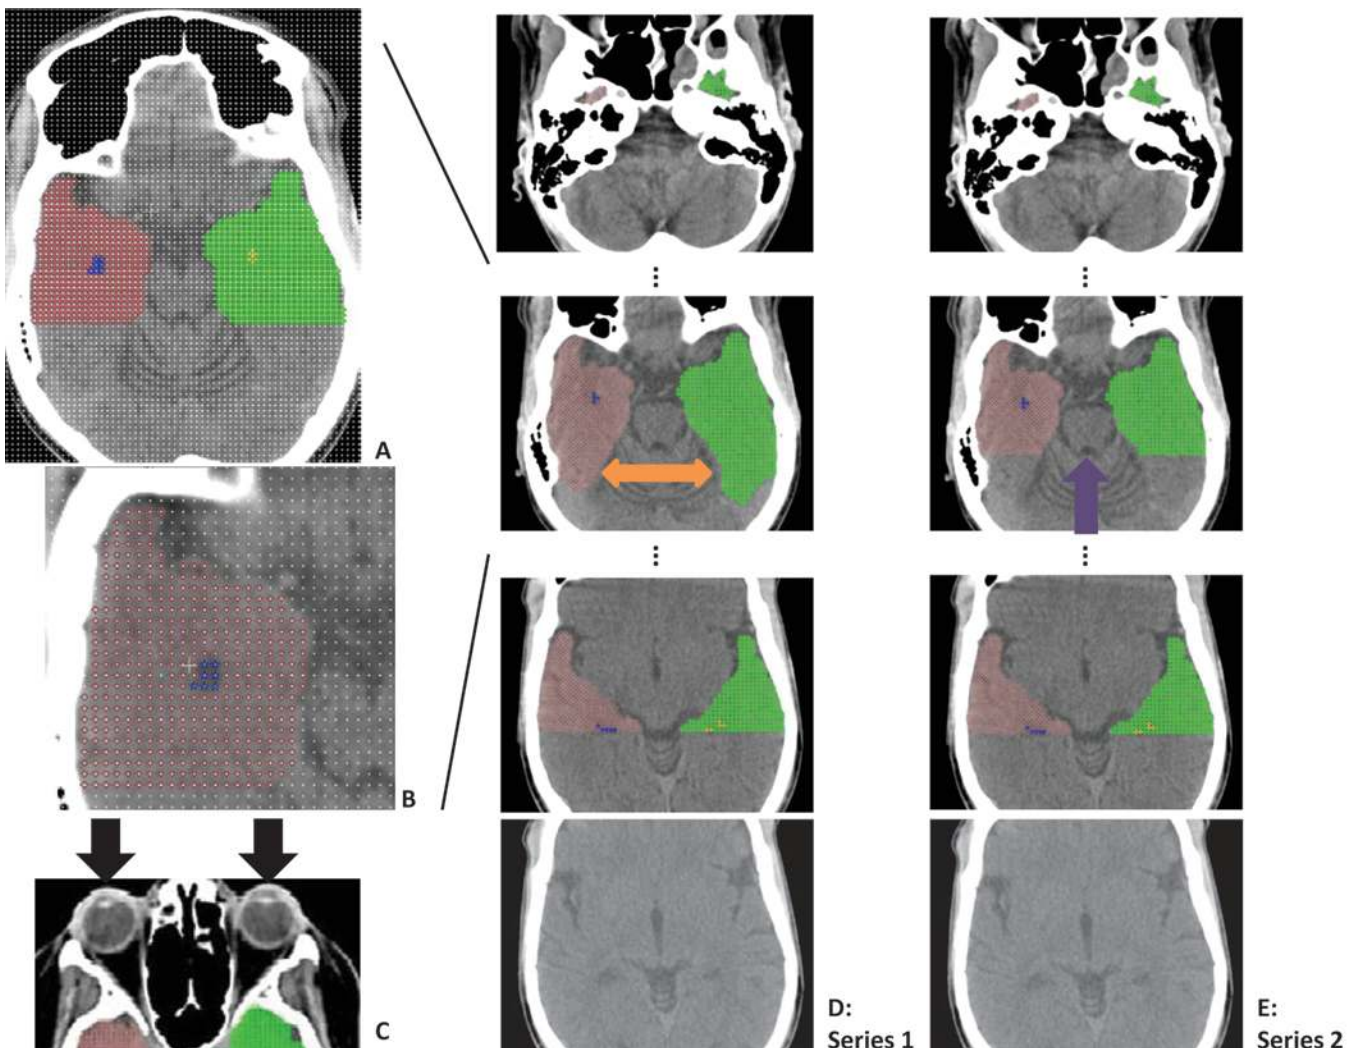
A: Randomly assigned grid with an intermarker distance of 2 mm, whole brain. The temporal lobe and horn areas are indicated in color. B: Randomly assigned grid with an intermarker distance of 2 mm. The right temporal lobe and horn area are indicated in color (magnified view). C: Representation of proper gantry angle in the CT scanner with both eye lenses captured on the same slice (black arrows). D: Series 1. The posterior border of the temporal lobe is the tentorium cerebelli surface when present (double-headed orange arrow) and the posterior margin of the collicular plate when the tentorium cerebelli surface is absent. E: Series 2. The posterior border of the temporal lobe is the floor of the fourth ventricle and the posterior margin of the collicular plate (purple arrow). Red indicates right temporal lobe. Green indicates left temporal lobe. Blue indicates right temporal pole CSF of the lateral ventricle. Yellow indicates left temporal pole CSF of the lateral ventricle.
